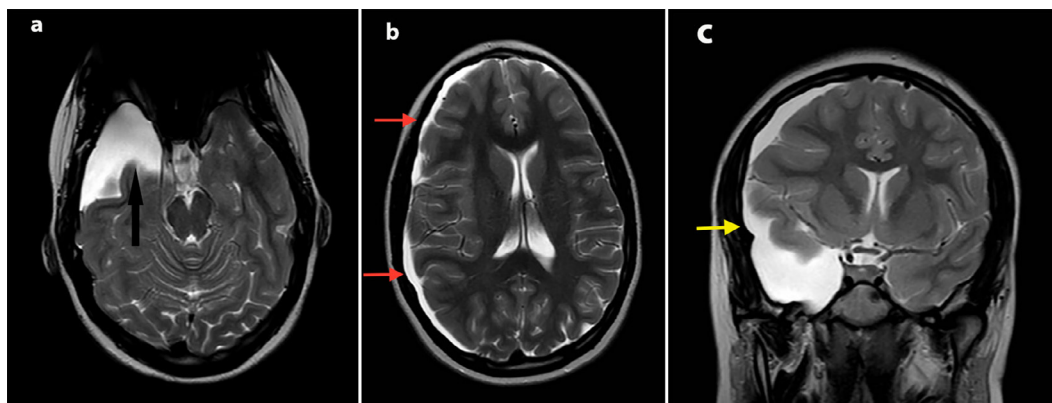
(a-c): Axial (a) T2 MR image of an extra-axial cystic lesion in 11-year-old, in the right middle cranial fossa following CSF signal (black arrow). Axial (b) T2 MR image of the subdural hygroma measuring 10 mm in maximal thickness seen along the entire right cerebral convexity (red arrows) causing mass on the underlying brain parenchyma and causing approximately 7-mm leftward midline shift. Coronal (c) T2 MR image showing communication between the right arachnoid cyst and the right cerebral convexity subdural hygroma (yellow arrow). (Color version of figure is available online.)
